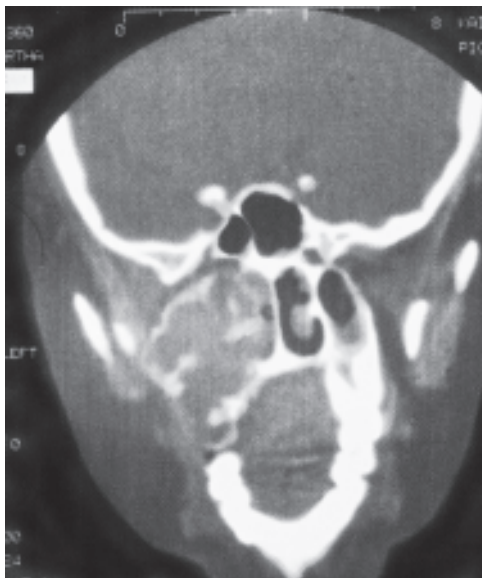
Radiographic appearance of large multilocular radiolucency of aneurysmal bone cyst in CT scan
